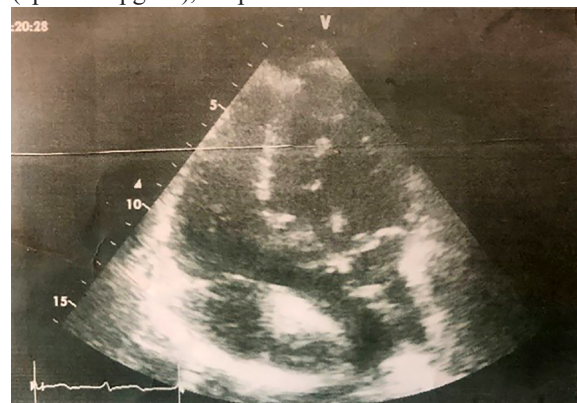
Apical five chamber view in congenitally corrected transposition of great vessels
